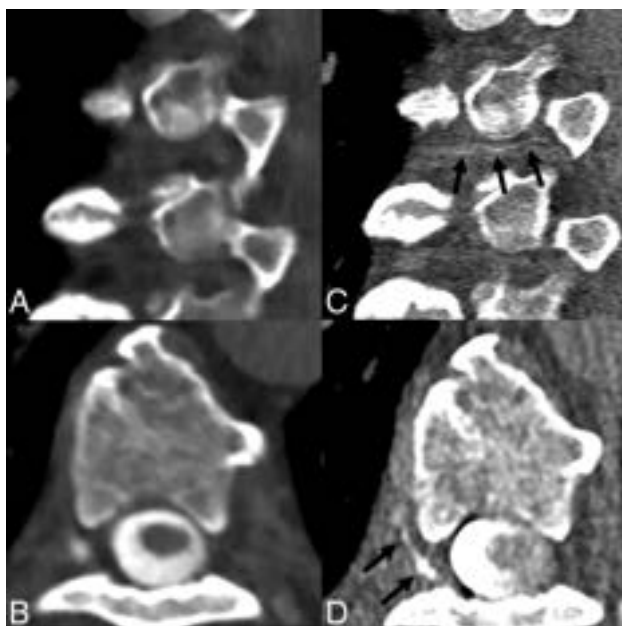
A 65-year-old woman with SIH confirmed by the ICHD-3 criteria, as well as brain MR imaging showing dural enhancement and venous distention (not shown). Sagittal and axial images during decubitus dynamic EID CTM (A and B, 0.625-mm section thickness) show no evidence of a CVF. Subsequent right lateral decubitus PCD CTM (C and D, 0.2-mm section thickness) demonstrates a clear right T6 CVF (C and D, arrows).
